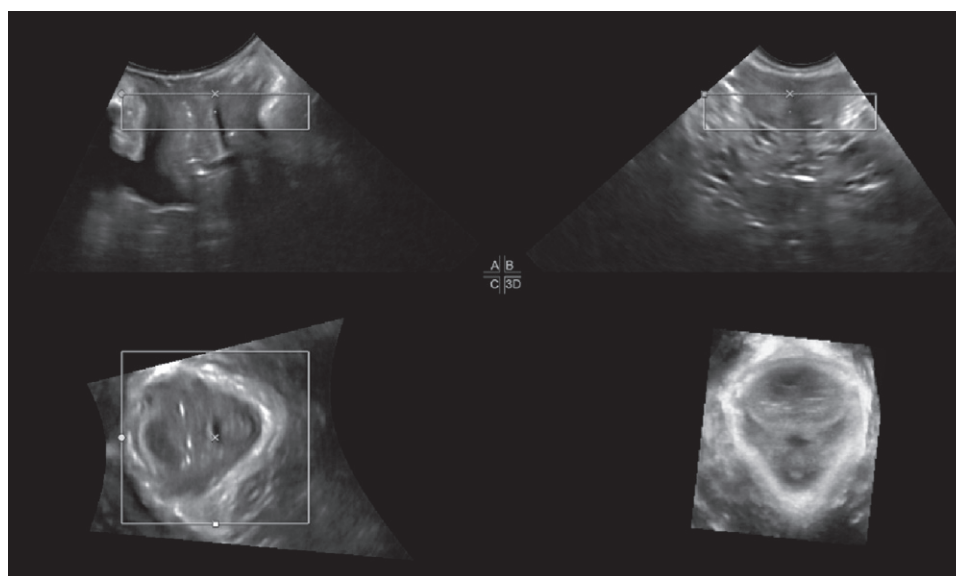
Rendered ultrasound volume (slice thickness of 1.5 cm) of a normal levator ani hiatus as seen and measured using 4D View.
